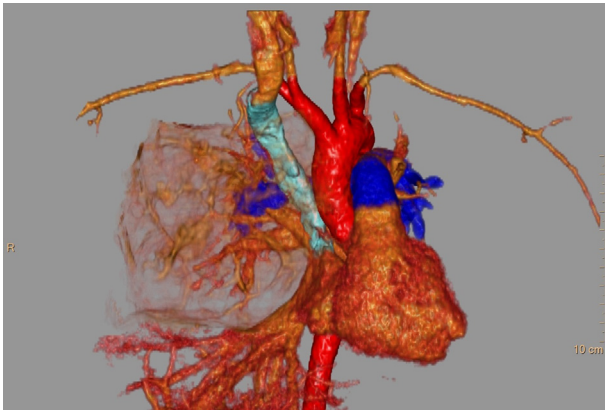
Compression of the tumor on the right atrium in a 3-dimensional configuration is shown on contrast-enhanced computed tomography.
